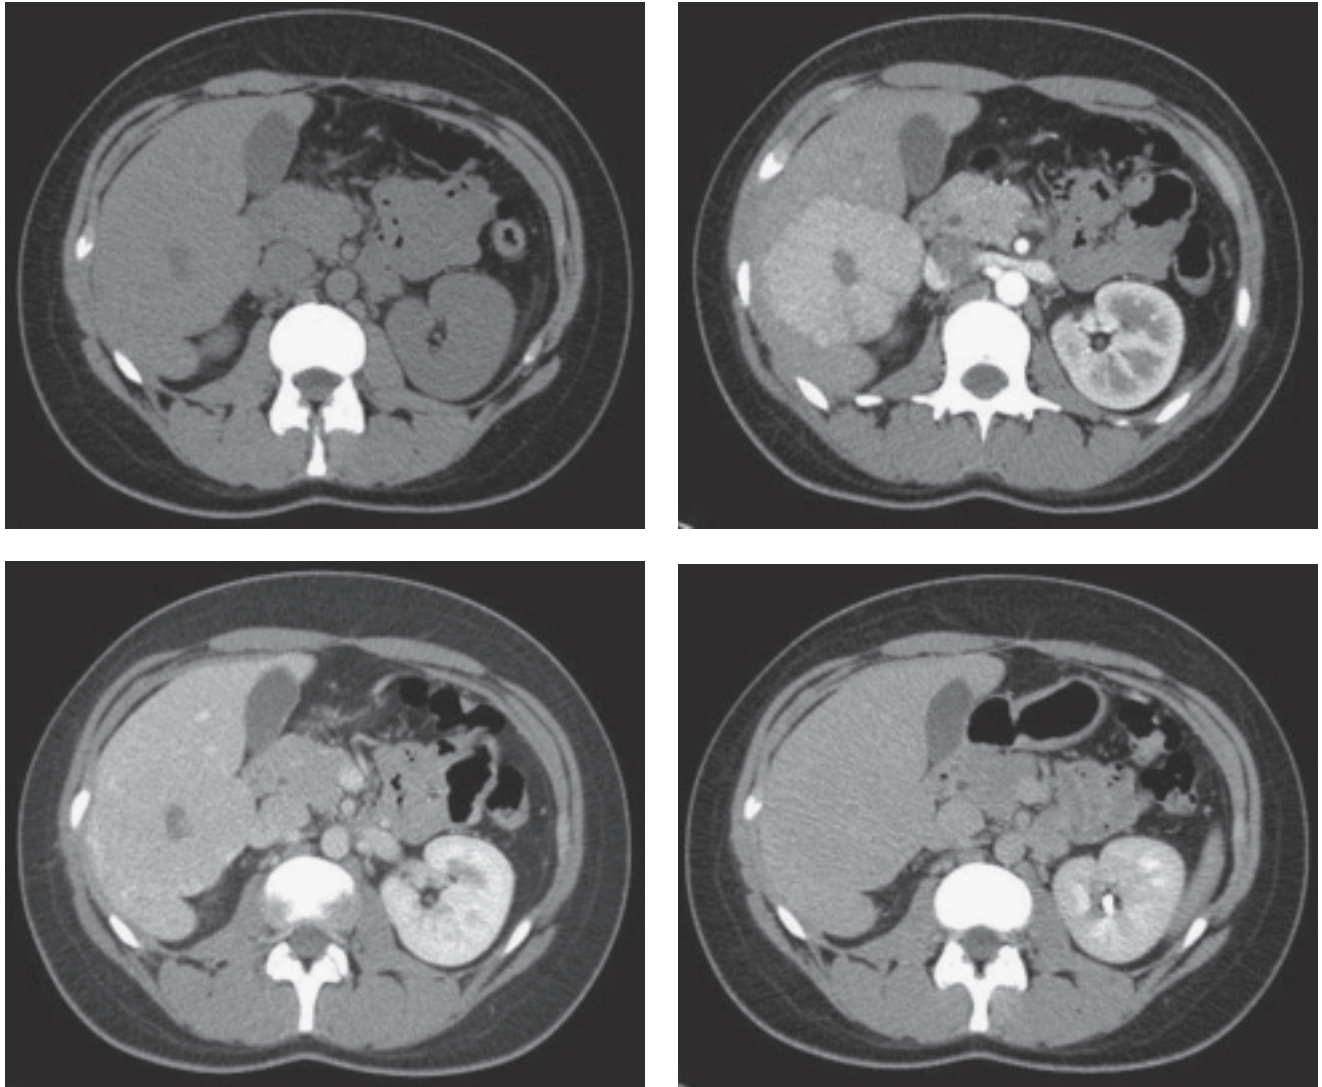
(A) Unenhanced axial CT image demonstrates an isodense mass within the right hepatic lobe with a central region of low density. (B) The mass demonstrates homogeneous increased enhancement on arterial phase imaging with a central hypodense scar. (C) On venous phase imaging, the mass is isodense to surrounding hepatic parenchyma with maintenance of the central hypodense scar. (D) On delayed imaging, the central scar fills in, with the entire lesion now isodense to surrounding hepatic parenchyma.
